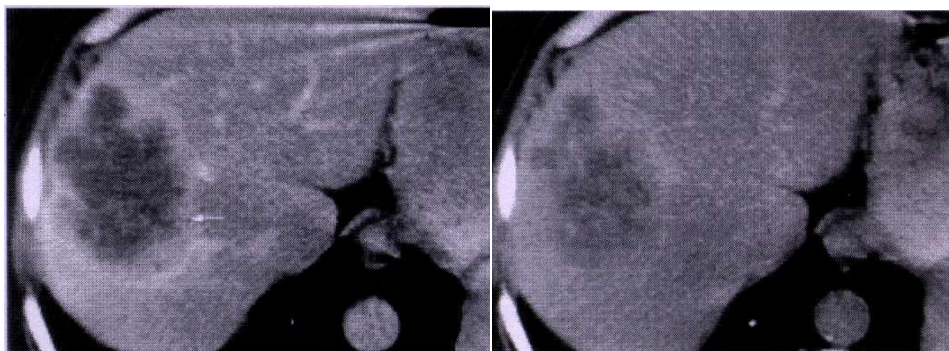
CT scanning: liver metastases in colon carcinoma
